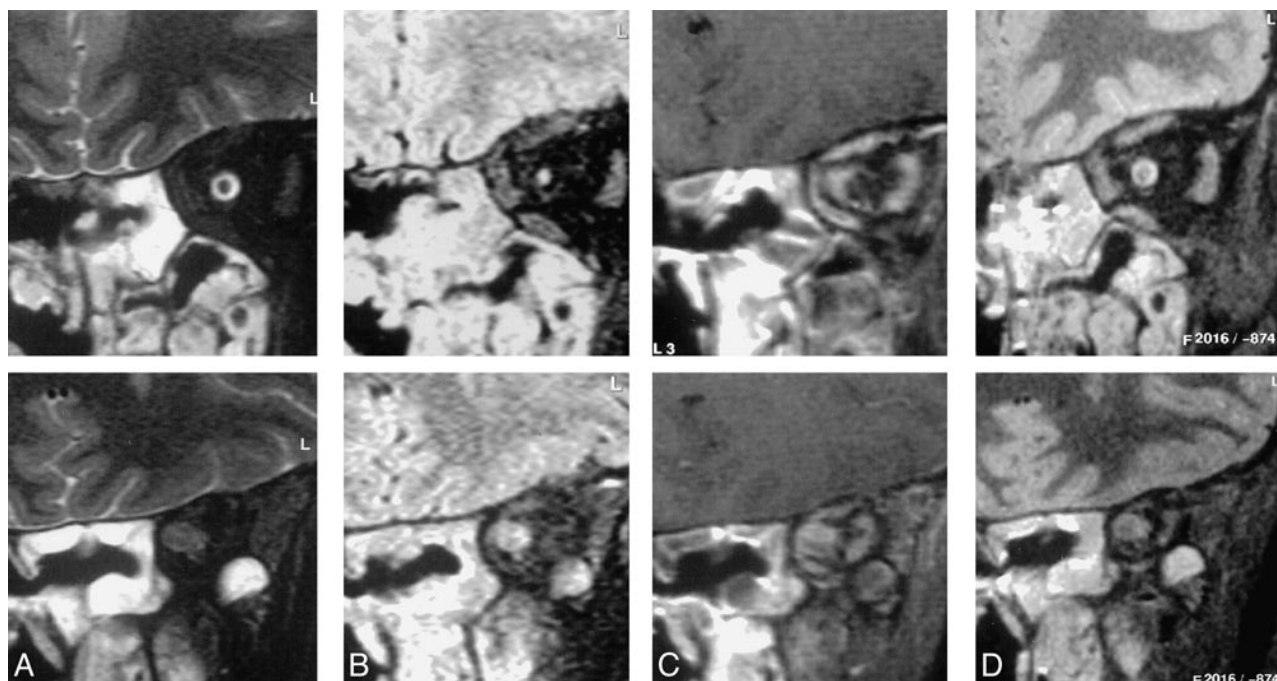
Coronal images through the orbits of a patient with an orbital apex meningioma. The sequences are T2-weighted SPIR (A), SPIR/FLAIR (B), T1-weighted SPIR with contrast (C), and STIR (D).
